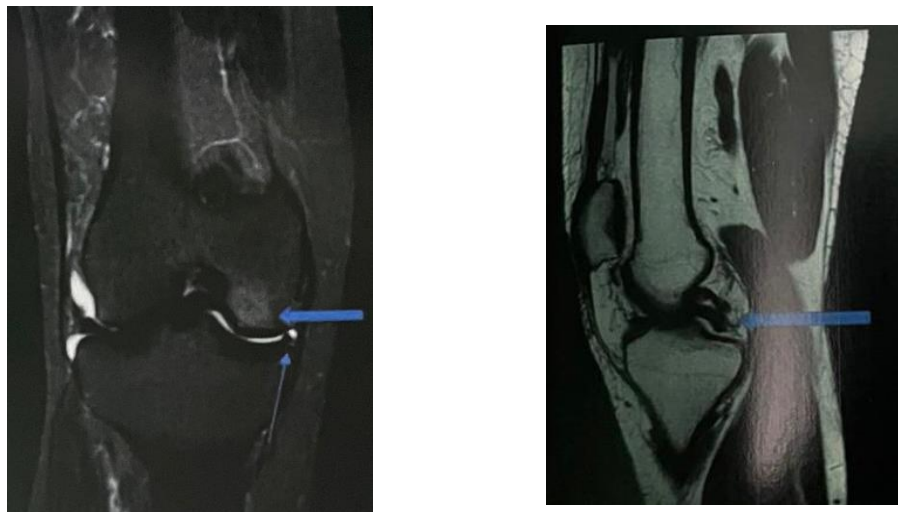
A & C MRI left knee in a 30-year-old patient following the history of trauma A & B. Axial and coronal PDFS images show radial tear of the medial meniscus with knee joint effusion. The hyperintense signal is seen involving the lateral condyle of the femur suggestive of bone contusion. (arrow) The note is made of a tiny para meniscal cyst. (Thin arrow) Oblique T2W image shows Double PCL sign in set handle tear of the medial meniscus (arrow)
